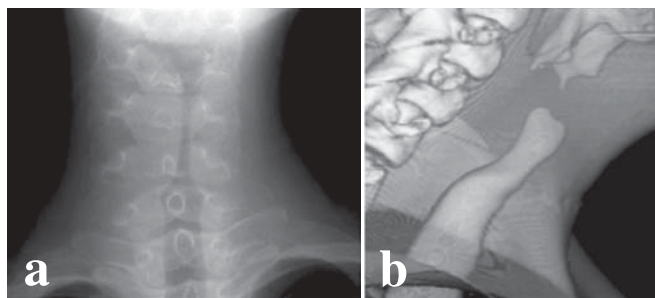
Neck X-ray showing narrow main bronchus (a) and three-dimensional reconstruction of the patient's computed tomography (CT) scan (b)
